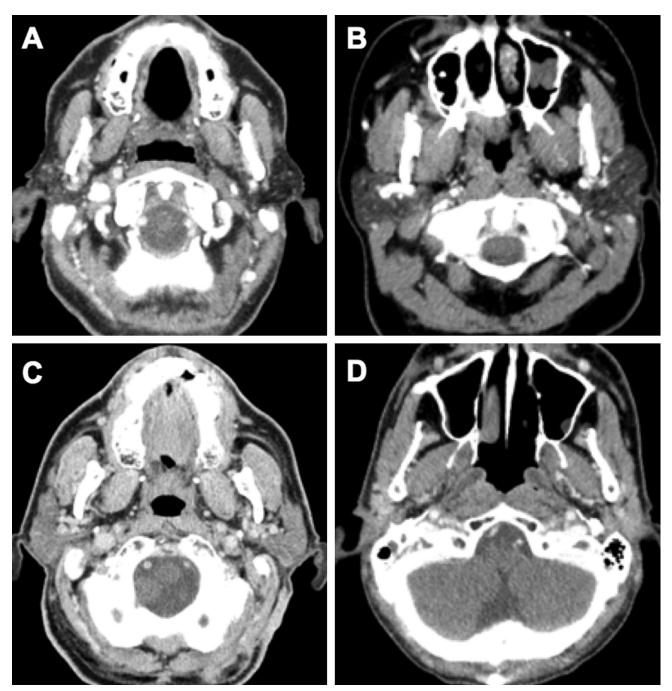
Normal CT appearance of parotid gland depending on the adipose tissue content of the gland in 4 different patients. (A) The density of the left parotid gland in the image is similar to the adjacent fat whereas the right parotid gland has slightly higher density in comparison with the adjacent fat. (B) Both parotid glands are hyperdense in comparison with the adjacent fat but hypodense in comparison with the adjacent muscles. (C) The parotid glands are hyperdense to the adjacent fat and slightly hypodense to the adjacent muscles. However, the density of the glands is slightly higher in comparison with the density of the glands on (B). (D) The density of the glands is isodense to the adjacent muscles.
